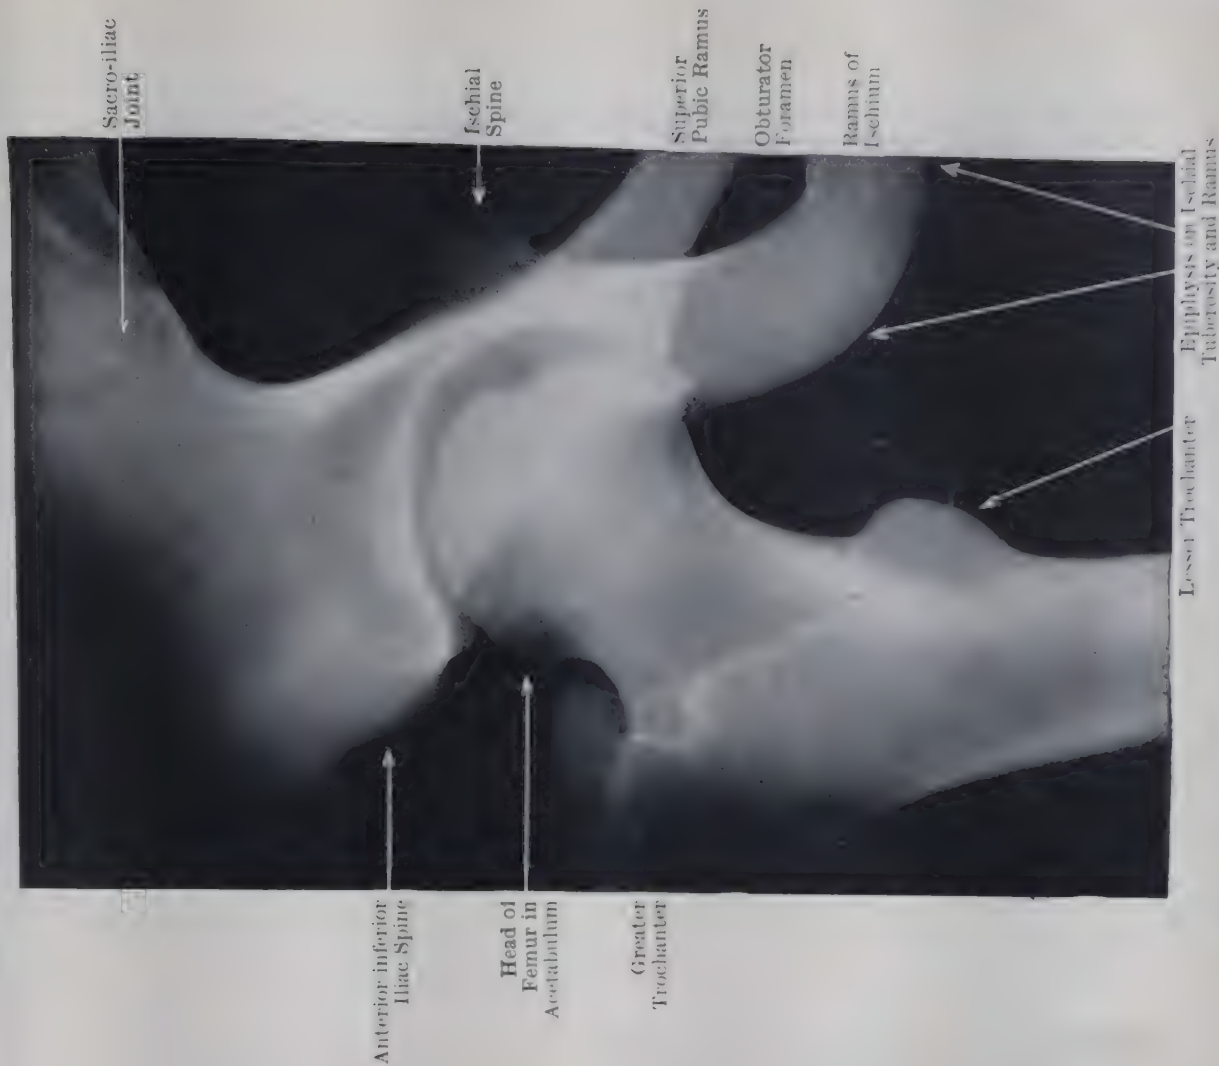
RADIOGRAPH OF HIP OF BOY AGED 14.
